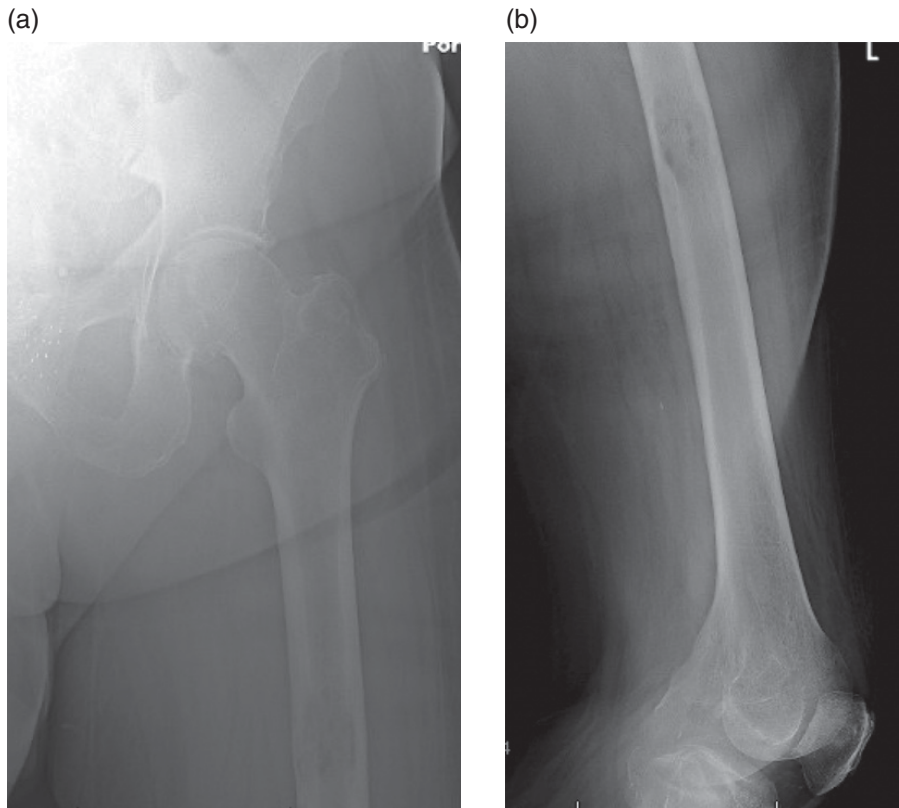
An anteroposterior (a) and lateral (b) radiograph of the left femur in a 72-year-old male with metastatic prostate cancer. There is a diaphyseal lytic metastatic lesion in the midshaft of the femur, resulting in thinned femoral cortices and impending fracture. The patient complained of severe thigh pain and difficulty ambulating. He was treated with a prophylactic femoral intramedullary nail placed to protect the entire femur, including the femoral neck.
